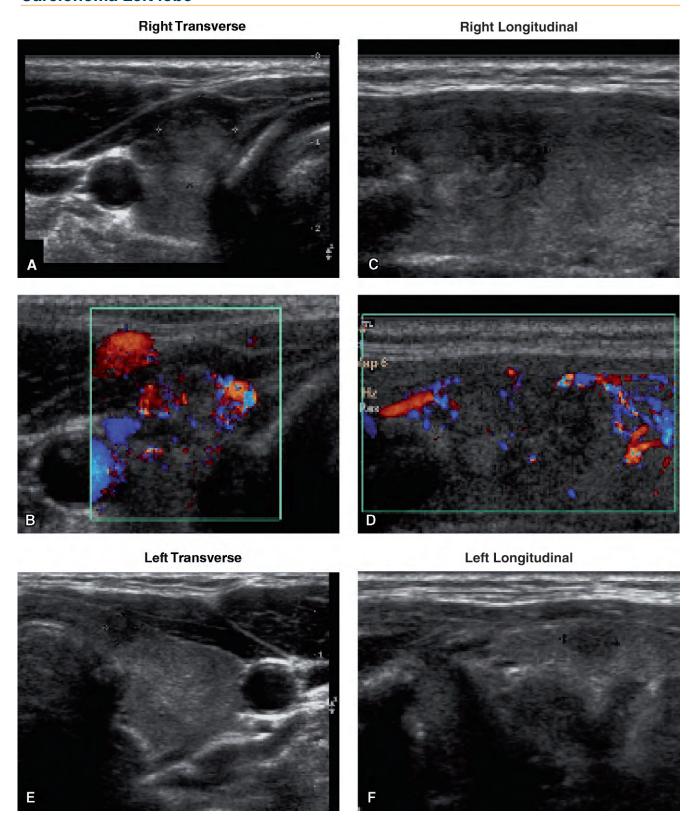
Ultrasound of papillary thyroid carcinoma (PTC) in the right lobe and micro-PTC in the left lobe. A, Right transverse, 9 x 10 mm. B, Color Doppler, right transverse. C, Right longitudinal, 15 mm. D, Color Doppler, right longitudinal. E, Left transverse, 4 mm. F, Left longitudinal.
